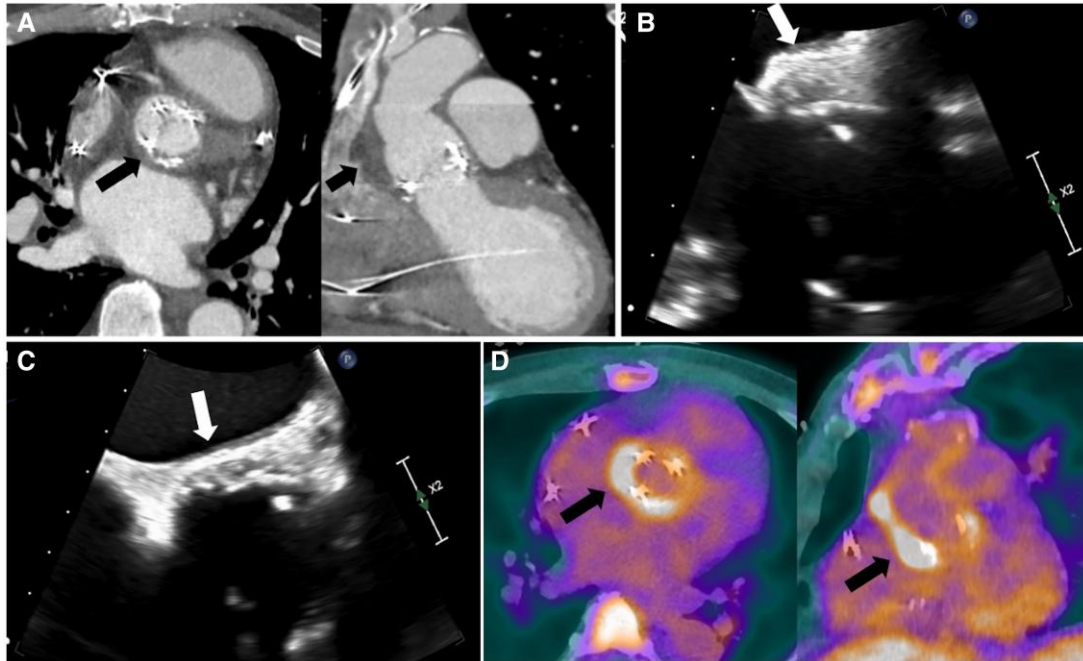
(A) Complex aortic para-valvular appearance with abnormal soft tissue density (black arrow) and para-valvular calcifications; posterior aortic root thickening with heterogeneous appearance seen on (B) long-axis and (C) short-axis transoesophageal echocardiogram images; (D) intense uptake by FDG positron emission tomography surrounding aortic valve prosthesis, concerning for para-valvular abscess.
